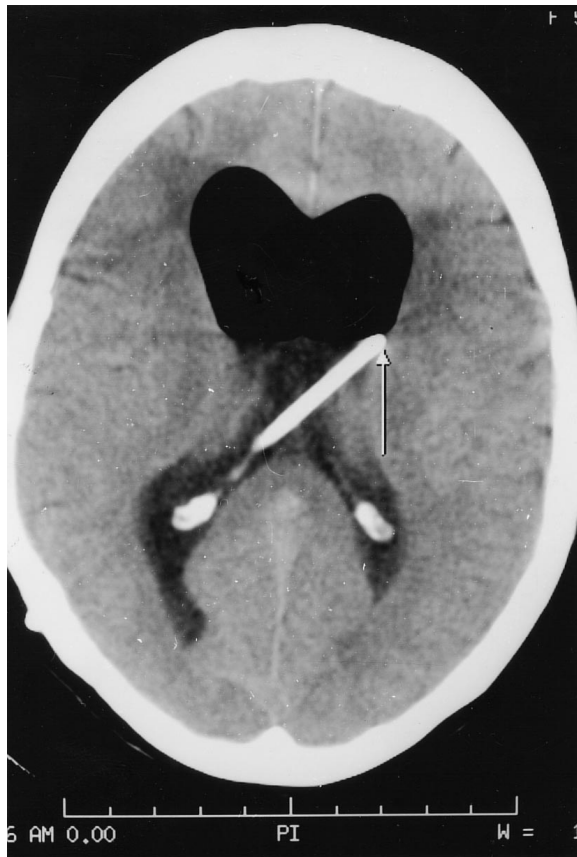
CT demonstrating the tip of the shunt catheter within the body of the left lateral ventricle (arrow). Note the air–cerebrospinal fluid level within both the lateral ventricles.
